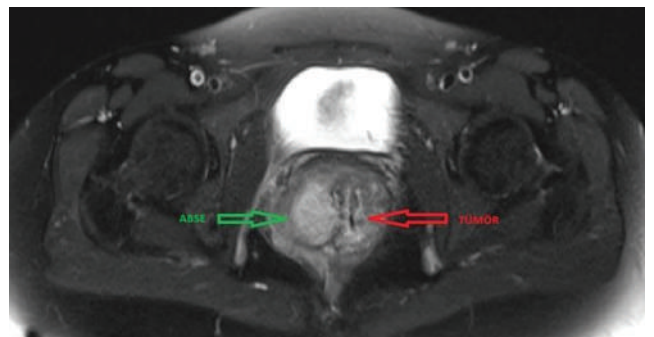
T2 secans. The appearance of the abscess on the patient's MRI imaging T2.
